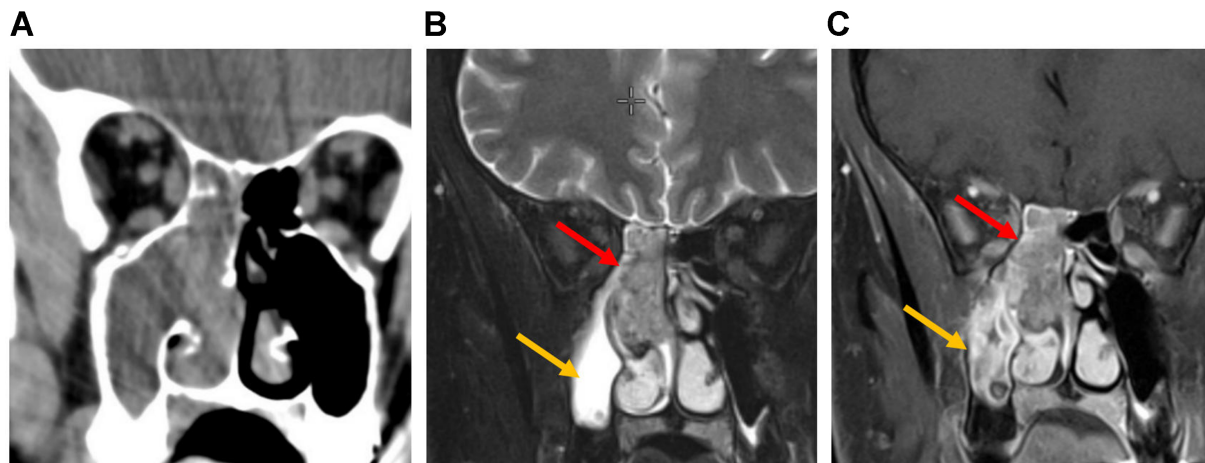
SNUC. (A) Coronal CT image of the paranasal sinus shows diffuse soft-tissue opacification of the right nasal cavity and ethmoid complex, with erosion of the ethmoid septa. The maxillary sinus is also opacified with lower attenuation; (B) Coronal T2-weighted MRI of the same patient shows intermediate tumor signal (red arrow). Maxillary sinus opacification appears hyperintense, consistent with retained secretions (yellow arrow); (C) Post-contrast T1-weighted MRI shows heterogeneous tumor enhancement (red arrow). The maxillary sinus demonstrates enhancing thickened mucosa, consistent with inflammatory disease (yellow arrow). SNUC: Sinonasal undifferentiated carcinoma; CT: computed tomography; MRI: magnetic resonance imaging.
